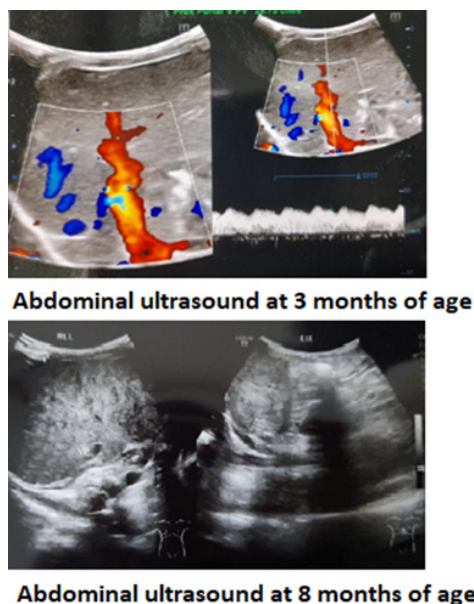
Abdominal ultrasound evaluation of the patient
